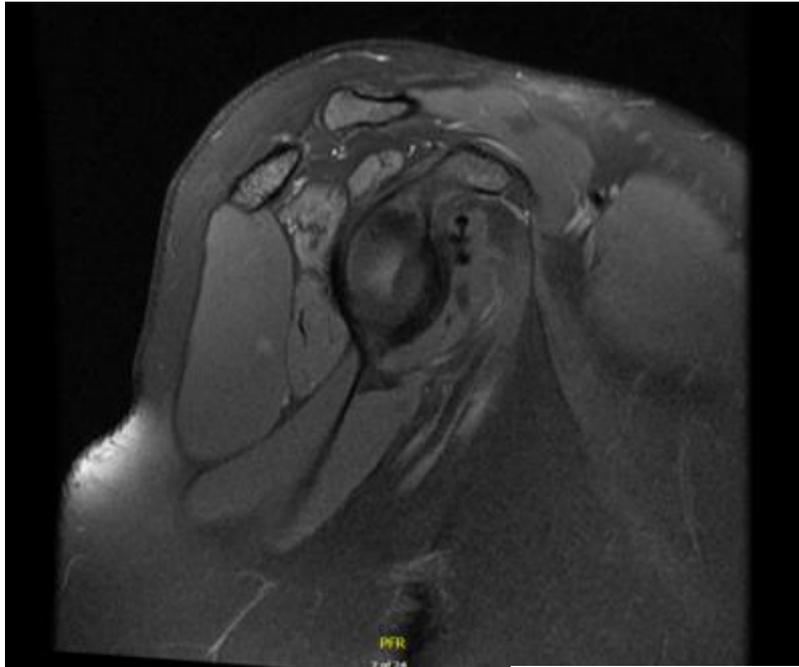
MRI of right shoulder (Sagittal) showing a detached labrum at the 3-7 o'clock.
